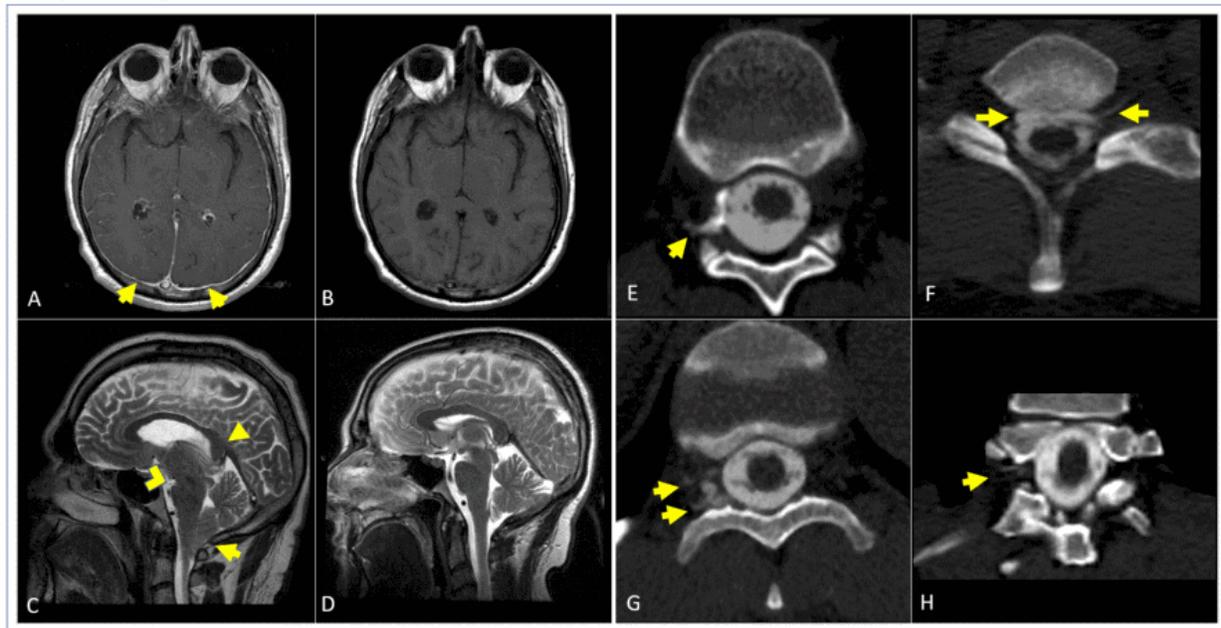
Imaging findings of intracranial hypotension and of CSF Leaks by subtype. MRI images in patients with (A&C) and without (B&D) intracranial hypotension. (A) Axial gadolinium enhanced T1-weighted magnetic resonance imaging showing diffuse pachymeningeal enhancement, as compared to (B) T1-weighted MRI without gadolinium enhancement. (C) Sagittal T2 weighted MRI - findings of ICH as compared to sagittal T2 weighted MRI of a normal brain (D), including decreased mamillopontine distance and decreased pontomesencephalic angle (◊), downwards drooping of the splenium(▶), and tonsillar ectopia (▶). (E) Axial CT myelogram imaging, showing tear of a meningeal diverticulum. (F) Axial CT myelogram showing large dural tear and ventral fluid collection. (G) Axial & (H) coronal reformation CT myelogram images showing extravasation of CSF contrast into adjacent venous channels
